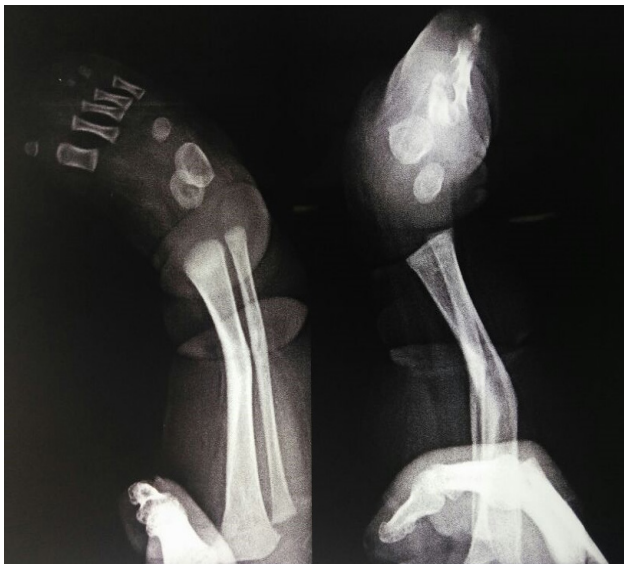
X-ray lateral and AP view of right leg with foot.
